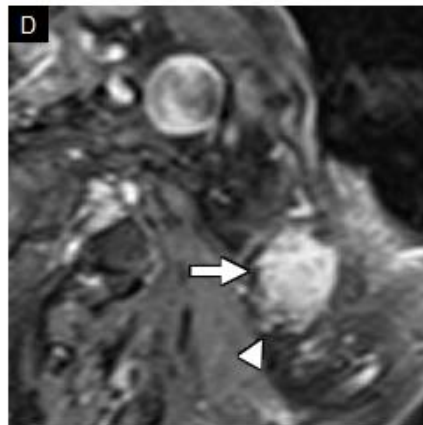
61-year-old man with aggressive left maxillary sinus squamous cell carcinoma. Axial T1WI C+ FS MRI (A) shows an enhancing mass centered within the left maxillary sinus (white arrow) with tumor extension into the left infrazygomatic masticator space (black arrow), retromaxillary fat, and pterygopalatine fossa. Note additional perineural tumor spread along CNV2 in the foramen rotundum (white arrowhead) with extension to the anterior cavernous sinus (black arrowhead). Axial 18F-FDG PET/MR with fused T1WI (B) confirms hypermetabolic tumor in these locations (black arrows), as well as (C) delineates perineural tumor spread along CNV2 in the foramen rotundum (black arrowhead) and invading the inferior orbital fissure (white arrowhead).
